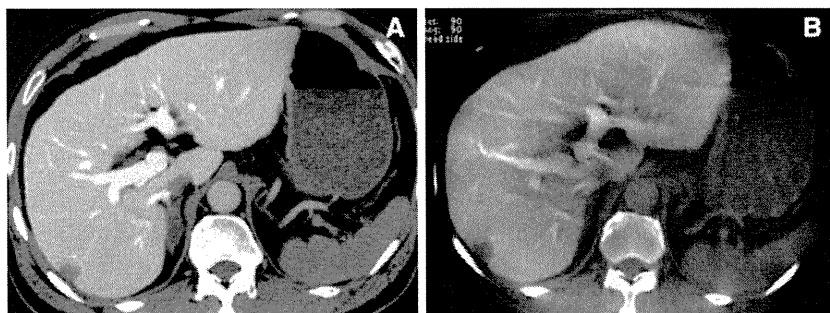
A 59-year-old man with HCC. A Conventional CTAP image shows a hypoattenuating mass in the right lobe of the liver. B CBCTAP image clearly shows the tumor along with a small artifact from the portal branches.
